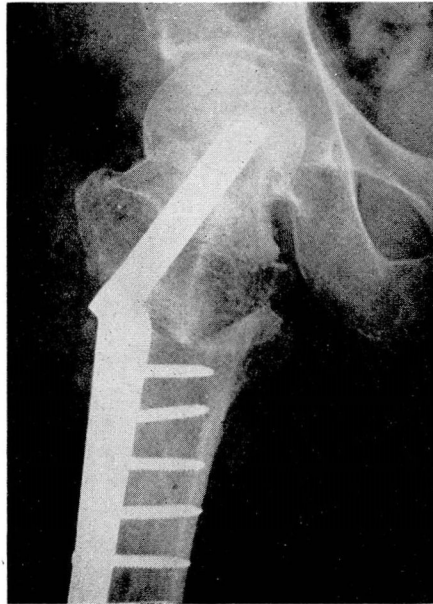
Roentgenogram showing position obtained by the osteotomy and rotation in case shown in fig. 12.
